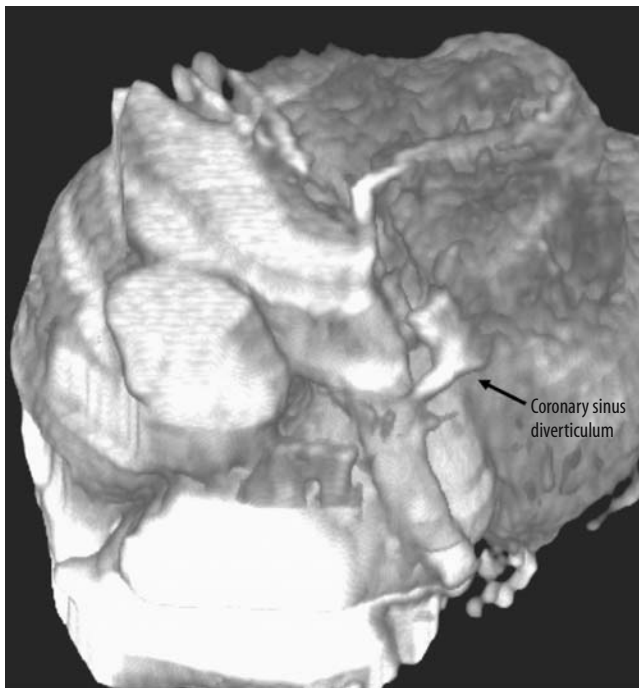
CT angiogram demonstrating a coronary sinus diverticulum (arrow).
